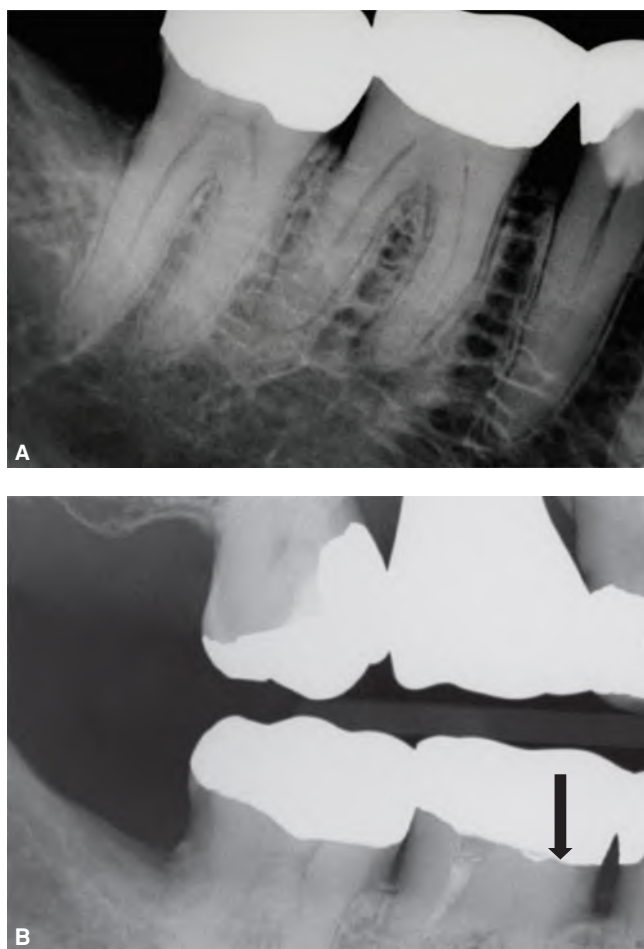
Use of radiopaque tracer for assessment of access preparation in a tooth with a calcified pulp chamber. A. Preoperative radiograph of the mandibular right first molar in a 73-year-old male showing a full coverage restoration and apparent obliteration of the pulp chamber. B. Intra-operative bite-wing radiograph showing access orientation with aid of radiopaque calcium hydroxide.
